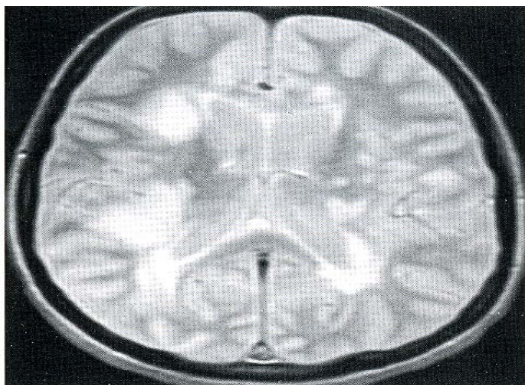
Axial proton density MRI: multiple bilateral deep white matter MS plaques
